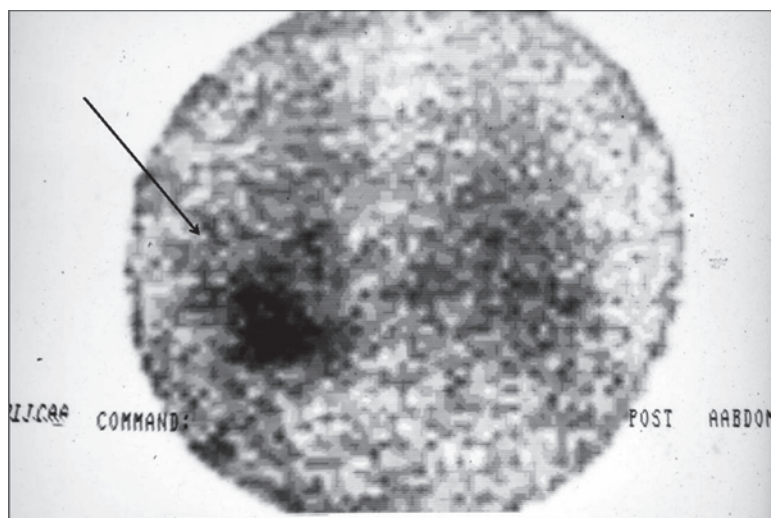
[¹³¹I]MIBG scintigraphy (72 h after applying 768 µCi [¹³¹I]MIBG), posterior view, showing uptake in the region of left adrenal (indicated with an arrow).
